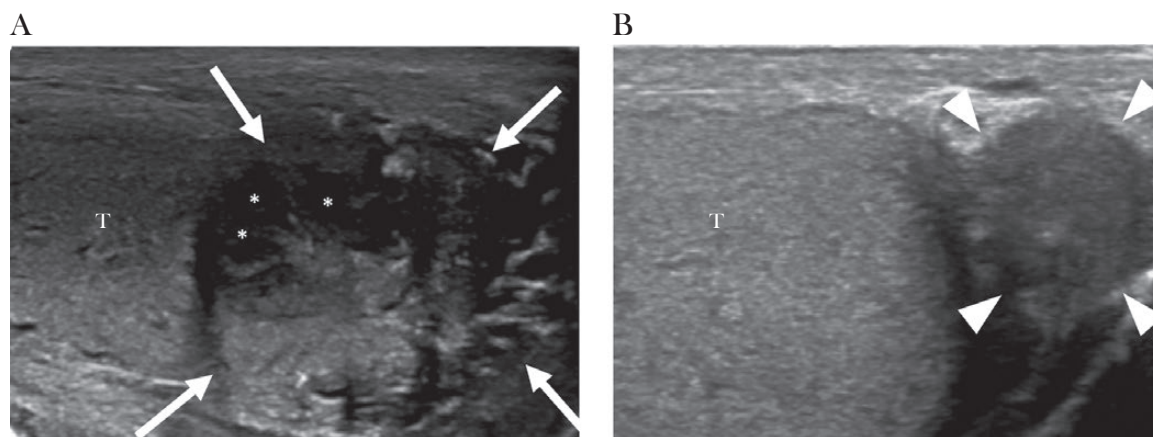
(A) Initial ultrasound image demonstrates enlarged and heterogeneous epididymal tail consistent with epididymitis (arrows). Several hypoechoic areas are also present (asterisks), consistent with abscesses. Doppler image showed increased vascularity of the left epididymal tail (not shown). Abbreviation: T, testis. (B) Follow-up ultrasound 6 months later demonstrates resolution of previous findings with a normal-appearing epididymal tail (arrowheads).
